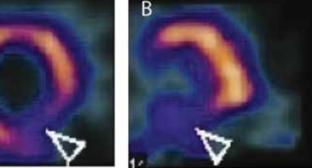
Combined topographic images of myocardial perfusion (A and B) and labeled stem cell scintigraphy (C and D). Decreased perfusion is seen in the inferolateral wall of the left ventricle (arrows) on perfusion images. Accumulation of labeled stem cells can be seen in the lateral and inferior wall, corresponding also to areas of decreased perfusion demonstrated on perfusion scintigraphy (full arrows).
